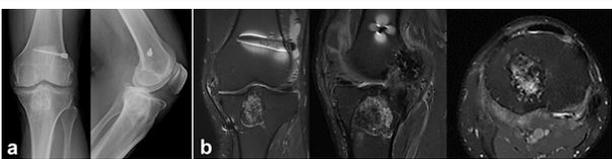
Anteroposterior and lateral radiographic views (a) and MRI sequences (b) of the knee joint 18 months after curettage and grafting.
